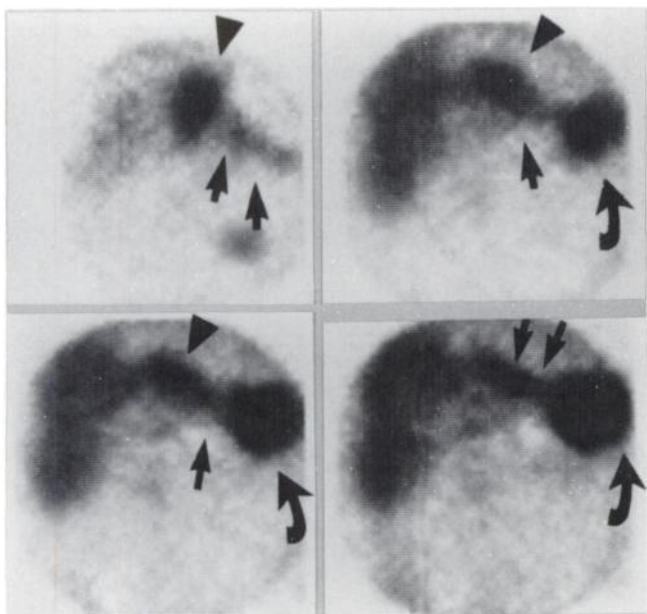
Coronal ¹¹¹In-WBC SPECT images of the upper abdomen from the second study. It demonstrates a wound abscess (arrow heads), a communicating tract (straight black arrows) and a splenic bed abscess (curved arrows).
